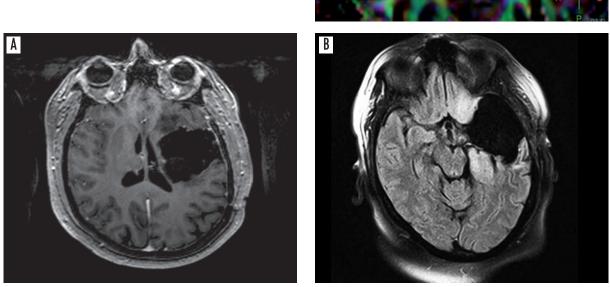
Patient KK. A) T2-weighted FLAIR image. B) T1-weighted contrast-enhanced image. Follow-up MRI one year after surgery. Subtotal tumour resection, small residual tumour in the anterior part of the orbital gyri
